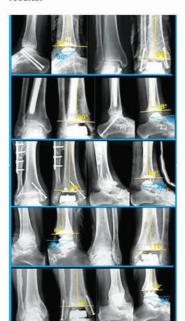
Our entire patient population with both pre and postoperative plain film radiographs
